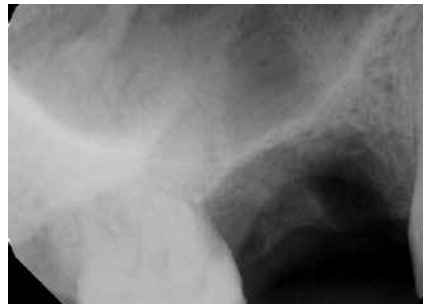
Post operative radiograph of extracted site, while maintaining the facial plate of bone.
